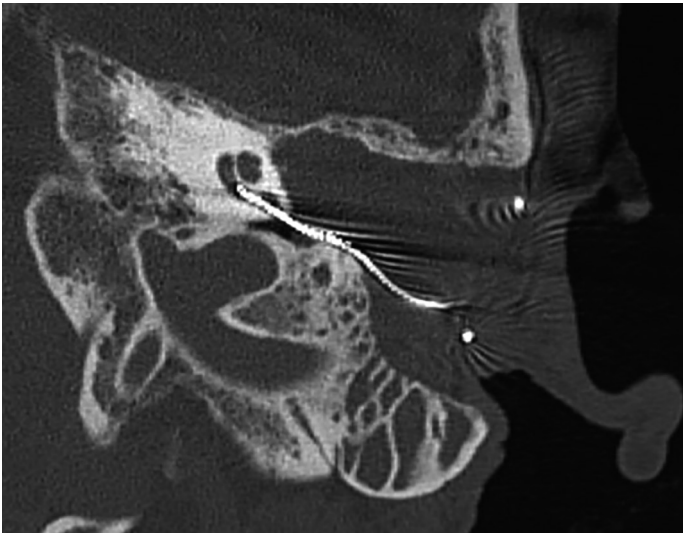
Temporal bone CT scan, axial section, showed a partial extrusion of the electrodes array from the cochlea.
